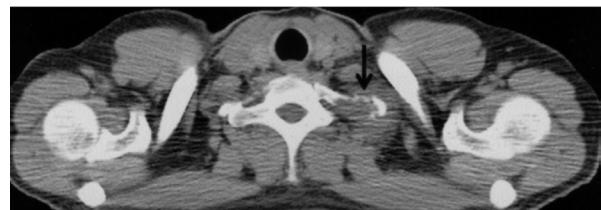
Chest CT revealed a bony destructive lesion at the left 1st rib. (arrow).
